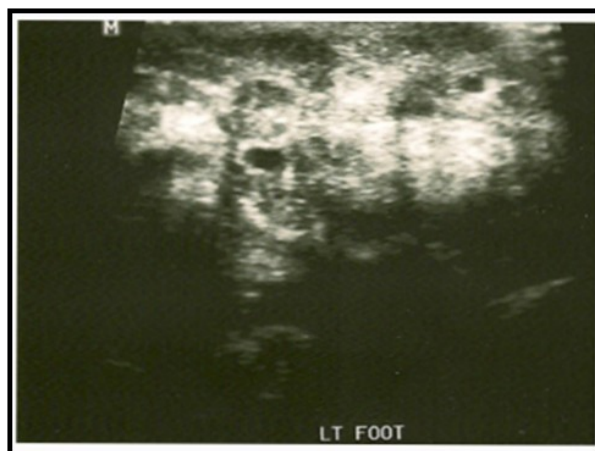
Ultrasonic imaging.
